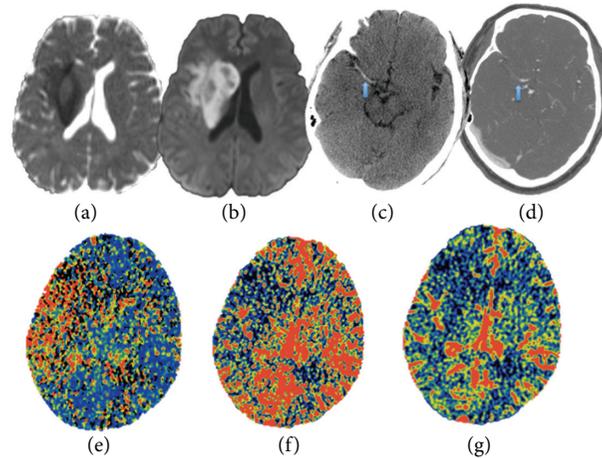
(a) and (b) ADC map and DWI map with restricted diffusion in the setting of cytotoxic edema from acute ischemic infarct in right MCA territory. (c) NECT showing hyperdense right MCA compatible with acute thrombosis. (d) CTA image with thrombosis in the corresponding segment of right MCA. (e), (f), and (g) CTP with elevated MTT, reduced cerebral blood flow, and blood volume in the right MCA territory.
